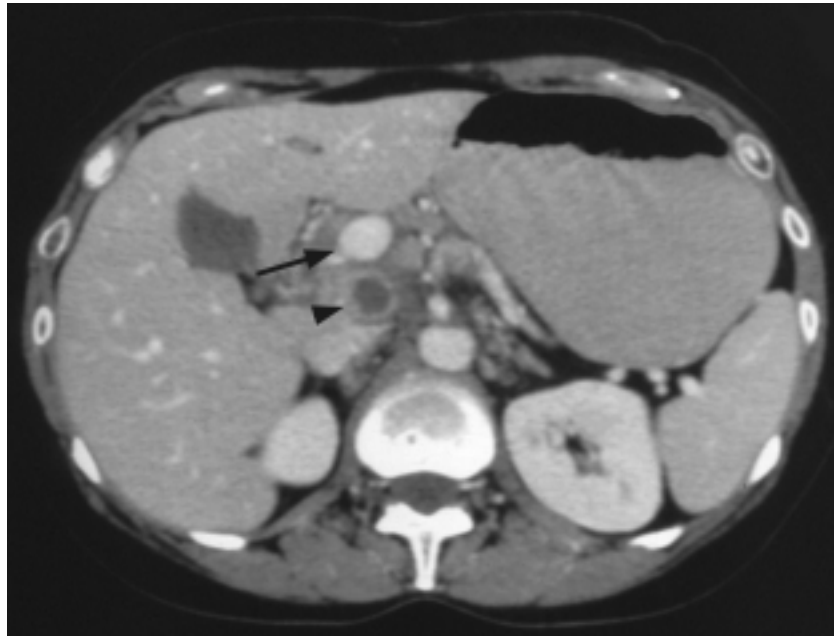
CT of the abdomen just above the level of the pancreatic head demonstrates round and ovoid low attenuation lesions with peripheral rim enhancement extending to the porta hepatis (arrowhead). This enlarged node measures 1.6×2.0 cm in diameter. Additional smaller rim-enhancing lymph nodes are present, which create a multilocular appearance of these nodes. The portal vein demonstrates good contrast opacification (arrow).
